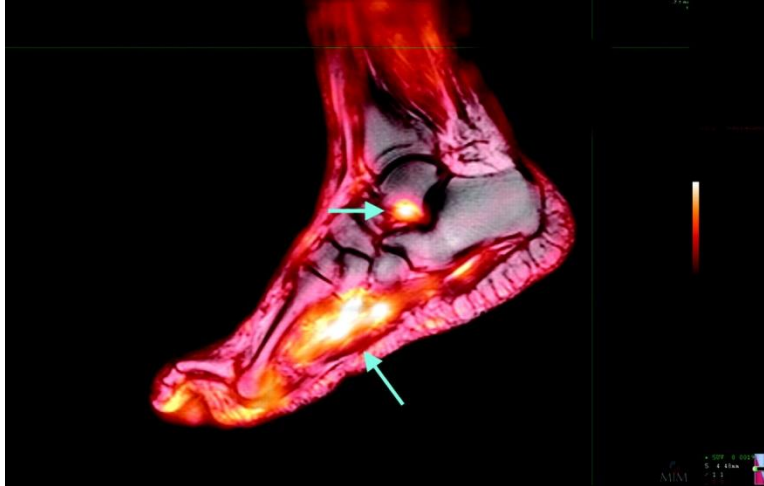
2 ^{18}F -FDG-PET and MRI images of a patient with diabetic foot and suspected bone infection. The FDG-PET image shows significant uptake in the soft tissue in the plantar aspect of the foot, and also reveals a focus of abnormal activity in the talus. Image reproduced from (47).
